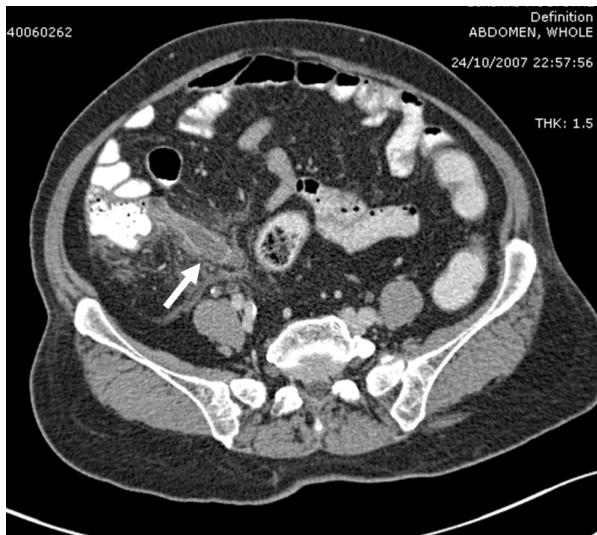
Axial enhanced CT scan of patient with perforated appendicitis. Dilated appendix was noted, measured 15 mm. in diameter, with defect in enhancing appendiceal wall, seen as disruption of enhancing line (white arrow). Periappendiceal fat standing was seen.
